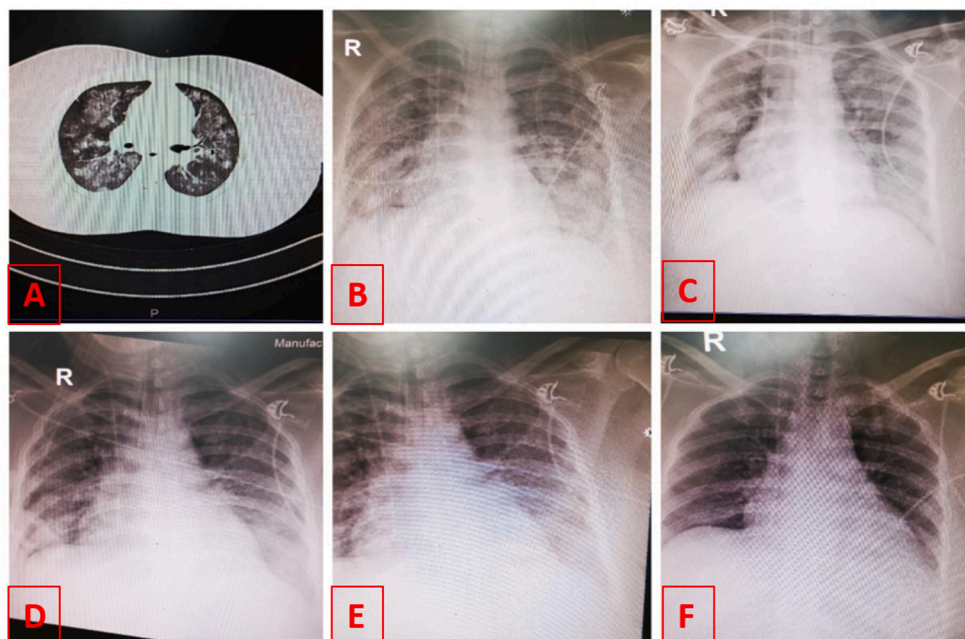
Showing HRCT scan of case 1 (A), consecutive chest x-ray showing clearance from B to F.
